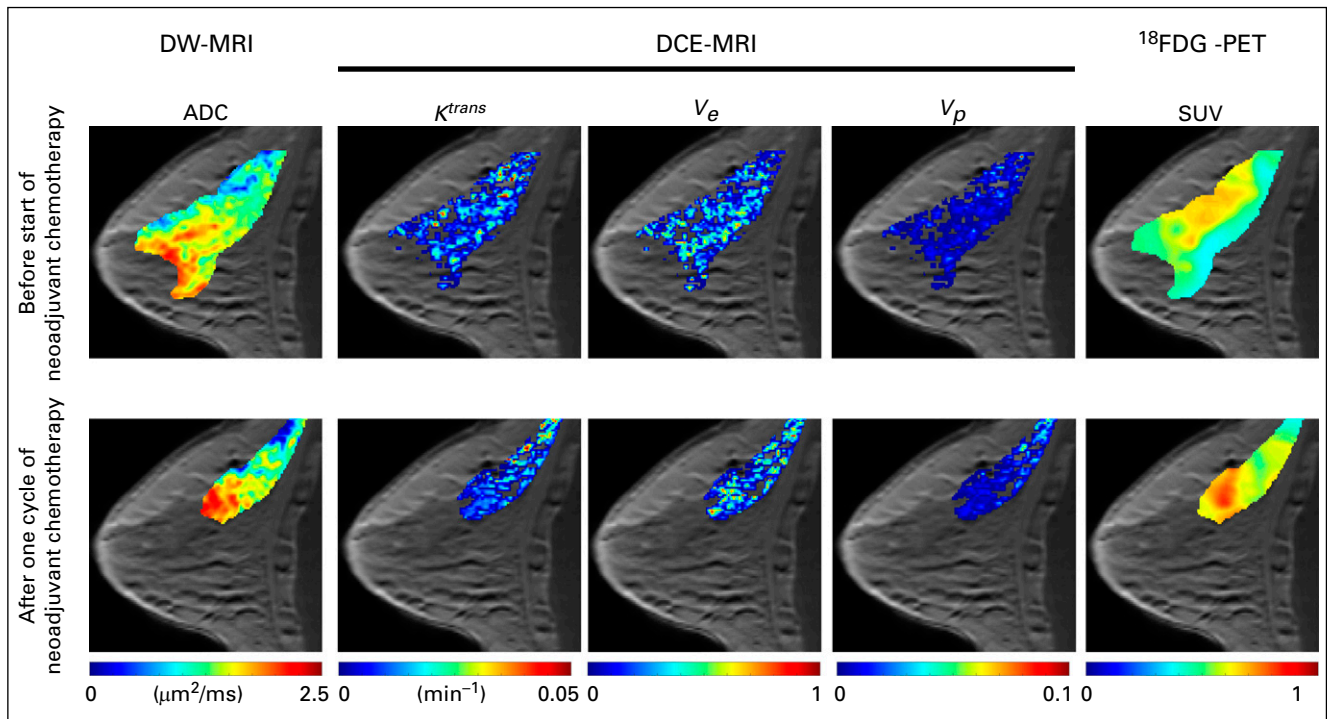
Example multiparametric data acquired in a patient with breast cancer before and after one cycle of neoadjuvant chemotherapy. Diffusion-weighted magnetic resonance imaging (DW-MRI) returns estimates of the apparent diffusion coefficient (ADC), which can be used to provide estimates of cellularity. Dynamic contrast-enhanced MRI (DCE-MRI) provides estimates of tissue blood flow and permeability (K^{trans}), extracellular-extravascular volume fraction (v_e), and plasma volume fraction (v_p). [^{18}F]Fluorodeoxyglucose positron emission tomography (^{18}F FDG-PET) provides estimates of the glucose standardized uptake value (SUV). These imaging measurements can be acquired noninvasively before, during, and after the start of therapy to characterize functional changes in tumor properties.
